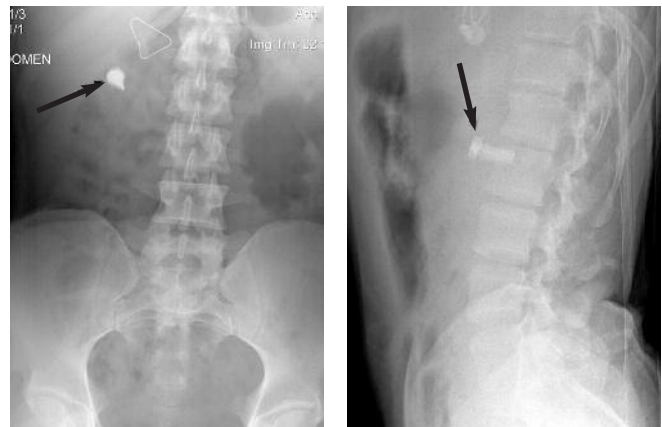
Plain film radiography showing bolt in right abdomen (arrowed). The paper clip marks the entry wound on the patient's back.
